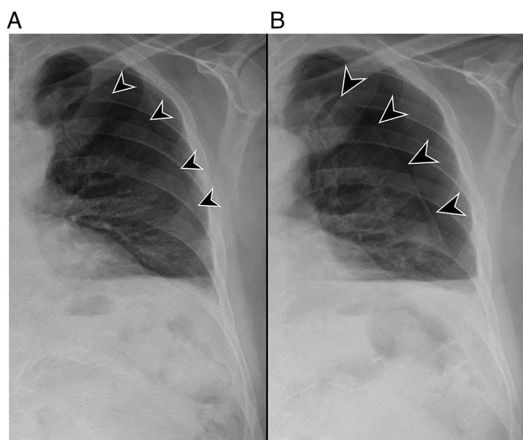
Two expiration views of chest x-ray performed (A) before (A) and (B) after 6 days of oxygen therapy, showing an increase in the size of the left pneumothorax (black arrowheads).
